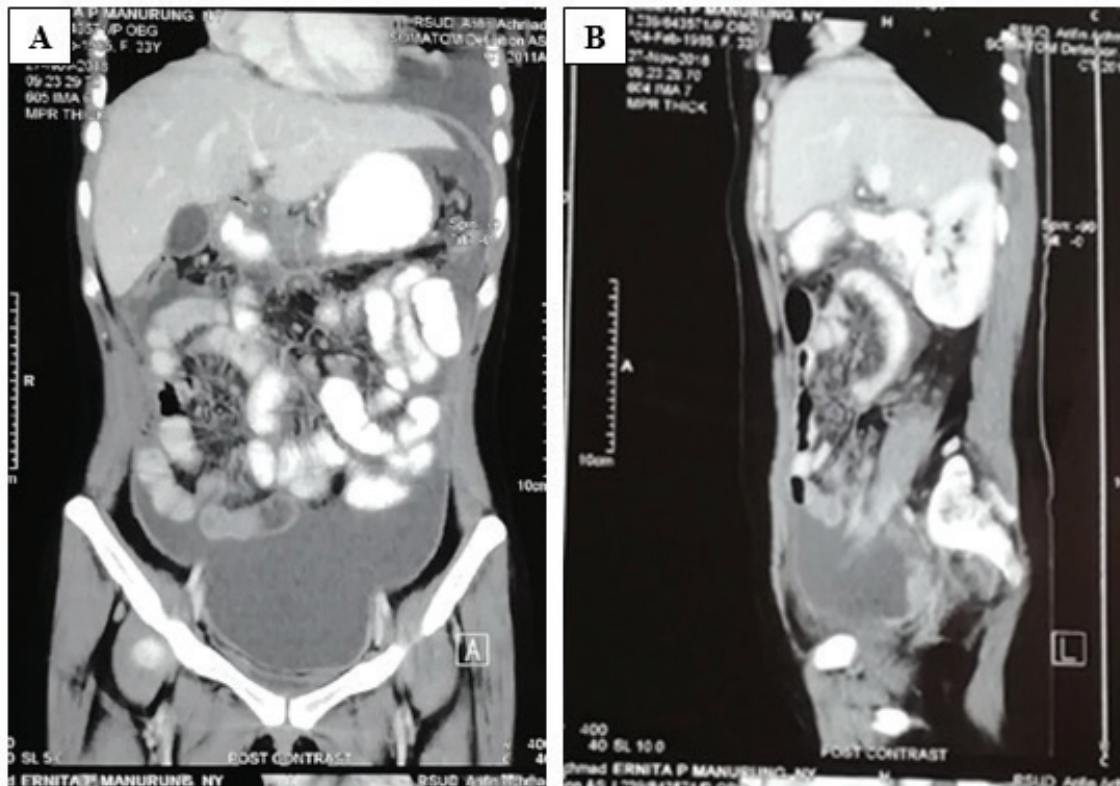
CT Abdominopelvic showed ascites, subdiaphragmatic nodules, enlarged parailiaca lymph nodes and adnexa mass at anterior posterior (A); lateral (B).
